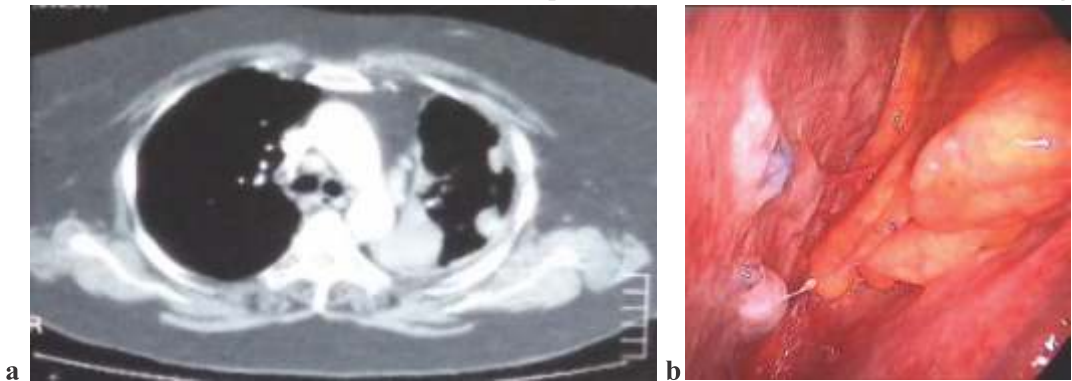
(a) contrast enhanced CT scan chest in a 65-year-old-lady showing left sided pleural nodules and thickening and (b) thoracoscopic visualization of nodules- confirmed as adenocarcinoma on biopsy.
